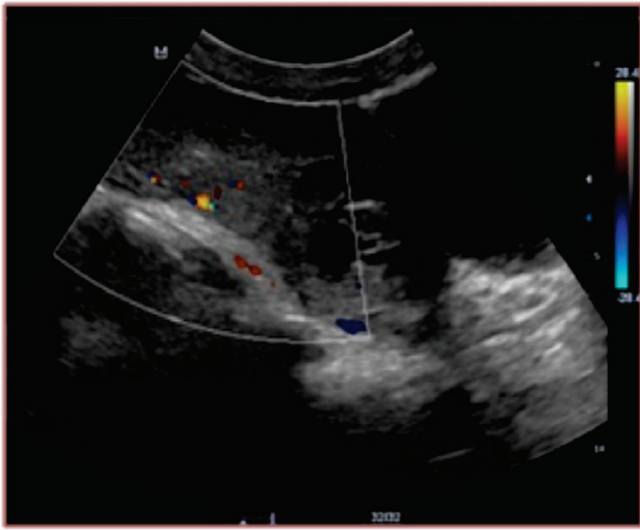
USG image showing increased vascularity on doppler
